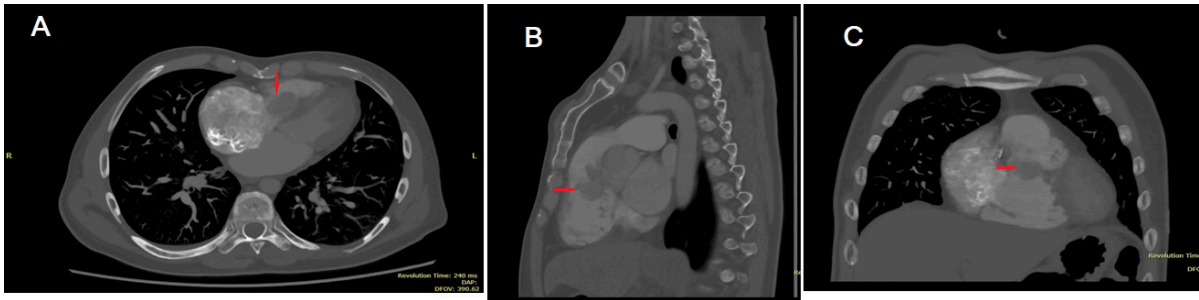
CT pulmonary angiography images. (A) Axial image showing dilatation of right atrium and a filling defect in RV (red arrow). (B) Sagittal image showing a lobulated aneurysmal pouch bulging into RV (red arrow). (C) Coronal image showing the same aneurysm. Image B and C show the aneurysm arising below pulmonary and aortic valves. RV, right ventricle.
